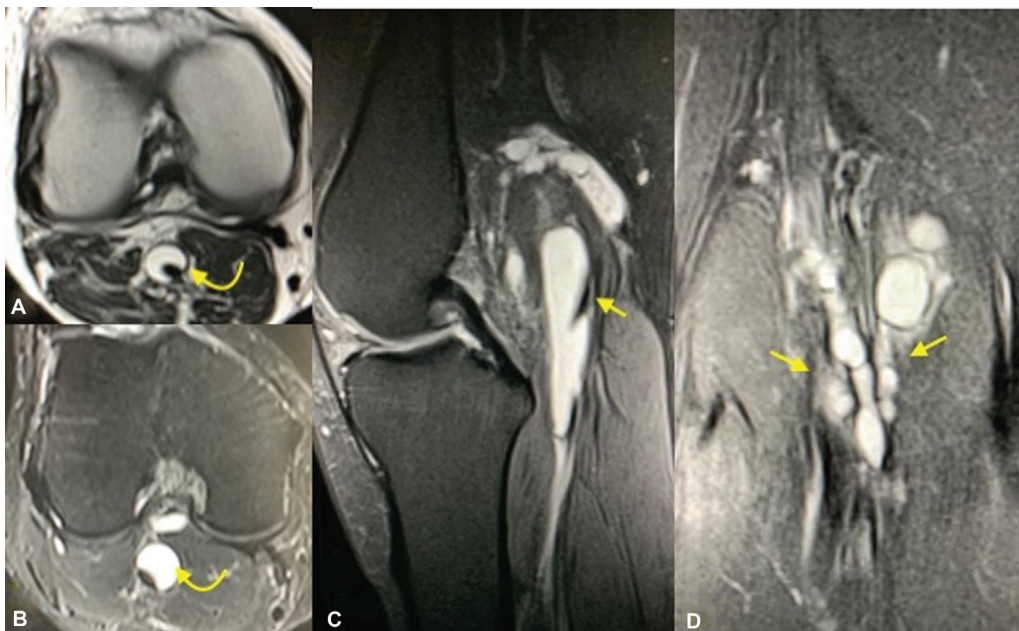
Cystic adventitial disease of the popliteal artery: T1-weighted axial (A), T2-fat-suppressed (T2FS) axial (B), sagittal (C), and coronal (D) images showing multiloculated cysts arising from popliteal artery wall (straight arrows). They appear hyperintense on T1-weighted and T2FS images (curved arrows), suggesting high mucoid content.
